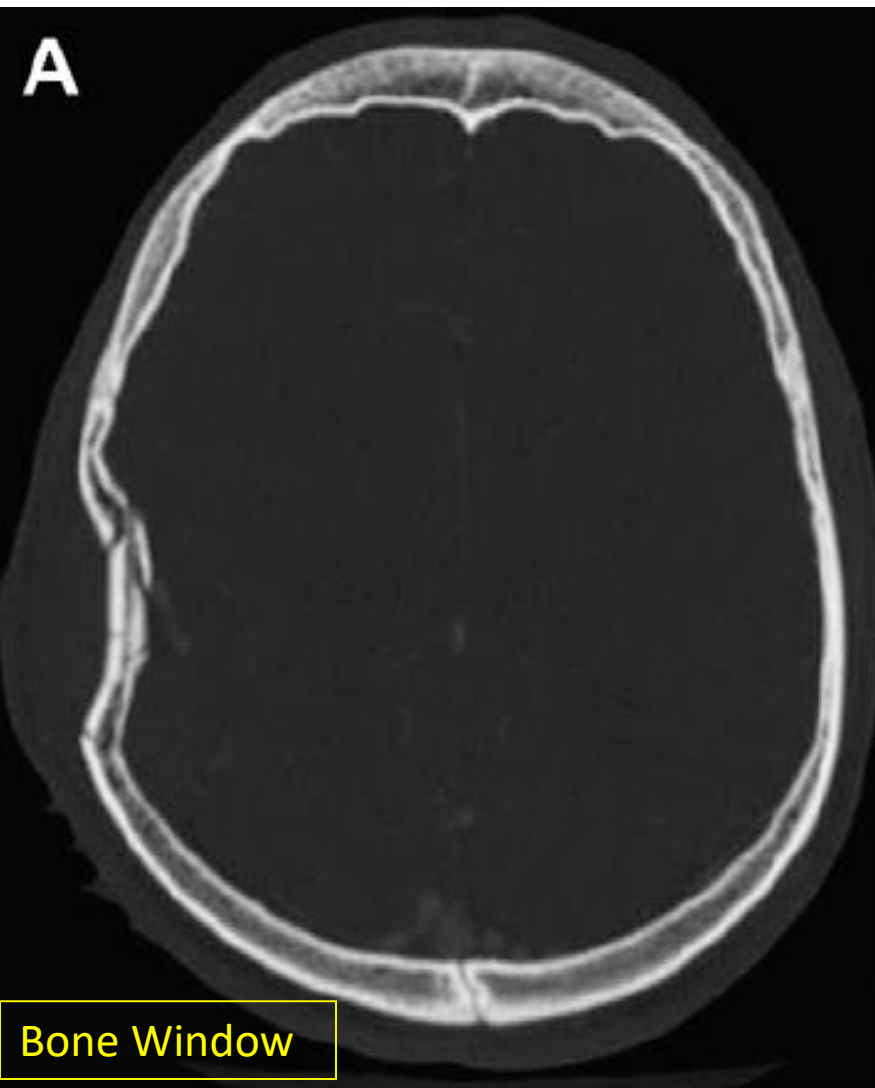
(A) Axial CT image showing a comminuted, depressed calvarial fracture. (B) Surface shaded 3D volume-rendered CT image of a comminuted, depressed calvarial fracture.
